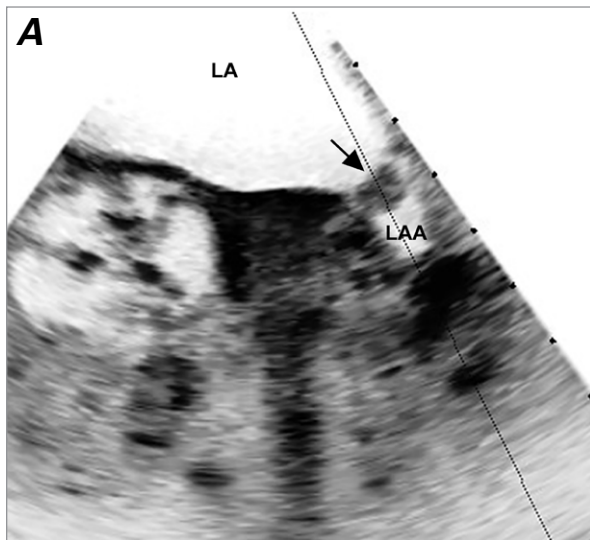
Patient 2. A) Transesophageal echocardiogram shows an 8 × 9-mm mass (arrow) floating freely in the left atrial appendage (LAA). B) Cardiac magnetic resonance (steady-state free precession sequence in the transverse plane) shows a faint mass (arrow) in the LAA.
